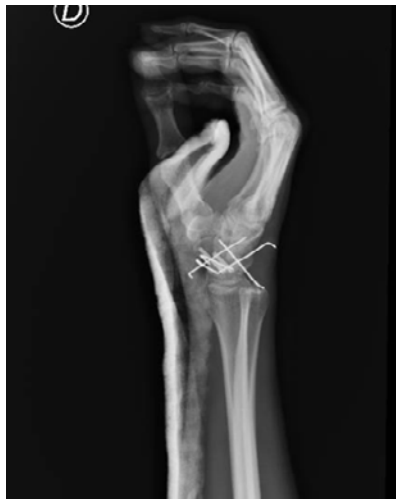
Lateral X-ray of the right hand and wrist taken immediately after surgery.
